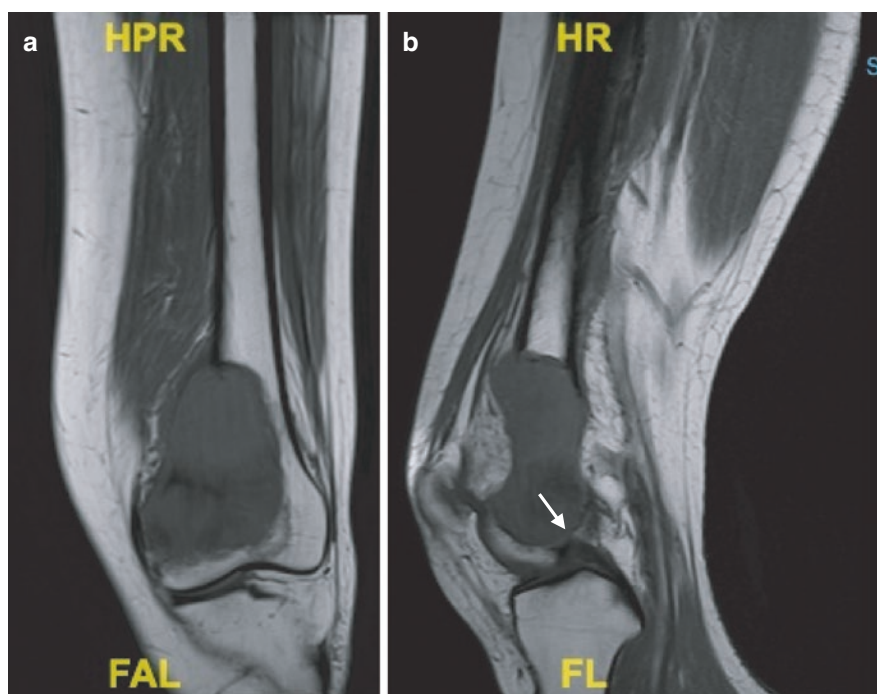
T1-weighted (a) coronal and (b) axial MRI images of distal femoral tumour. No effusion to suggest intra-articular involvement. Tumour is close to the posterior cruciate ligament (arrow). While an intra-articular resection is preferred, careful division of the cruciate ligaments at the tibial attachment is required to ensure no contamination should tumour extend along the cruciate ligaments
